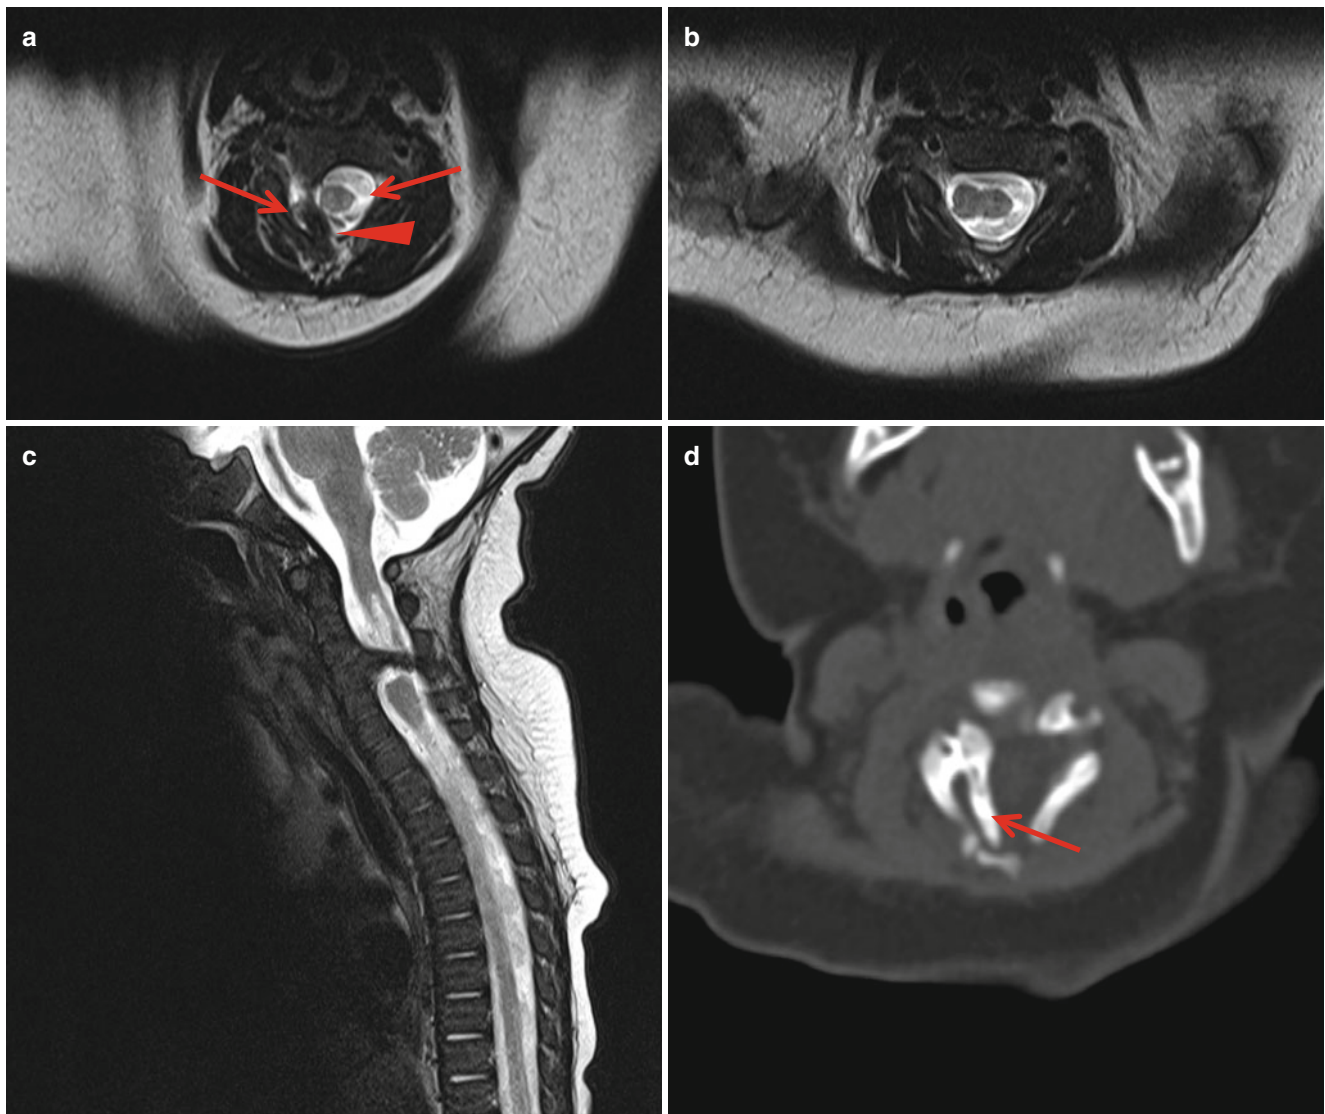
Diastematomyelia. (a) T2-weighted axial image shows two hemicords (*arrows*) are split by bony bridge (*arrowhead*). (b) Two hemicords are reunited distal to the bony bridge. (c) Sagittal image
